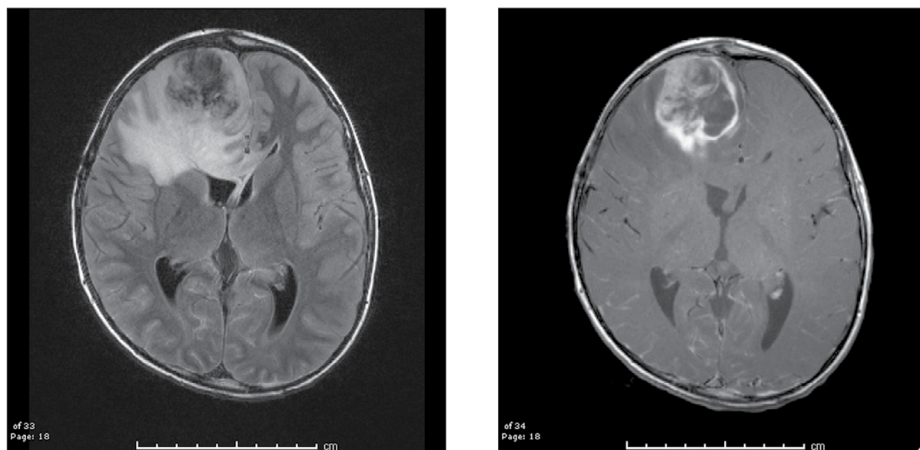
Axial FLAIR (left) and contrast enhanced (right) MR imaging of a 10 year old boy with NF1 and glioblastoma.
